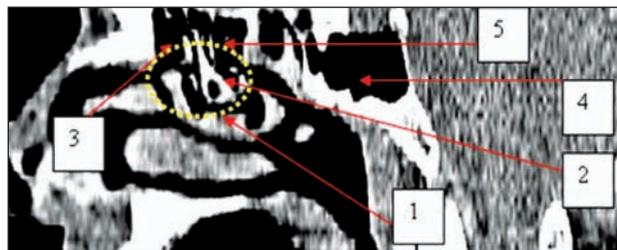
Paranasal sinuses CT scan, left sagittal reconstruction: 1. trilobular concha bullosa; 2. pneumatization of the uncinete process, elongated; 3. Agger nasi cell; 4. hype-pneumatization of the sphenoid sinus; 5. ethmoidal bulla
